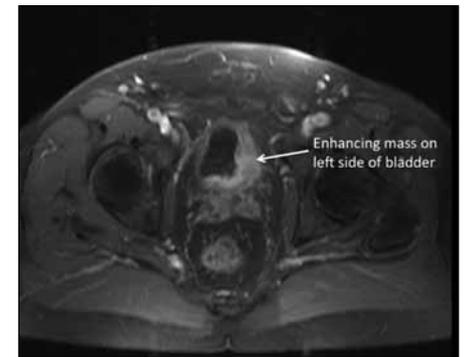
MRI of the male pelvis demonstrating an enhancing mass on the left side of the bladder. This patient was found to have high grade muscle invasive urothelial carcinoma
